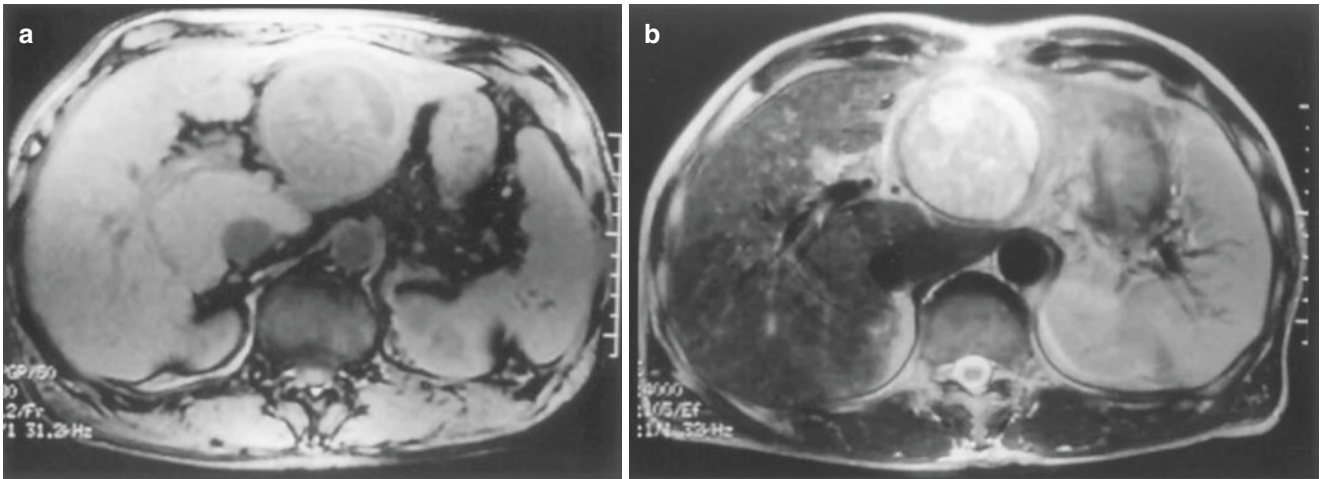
Cystadenocarcinoma; MRI images. MRI with T1 intensification shows iso-intensity in the tumor with high intensity in its rim (a). MRI with T2 intensification shows high intensity in the tumor with low intensity in its rim (b)
